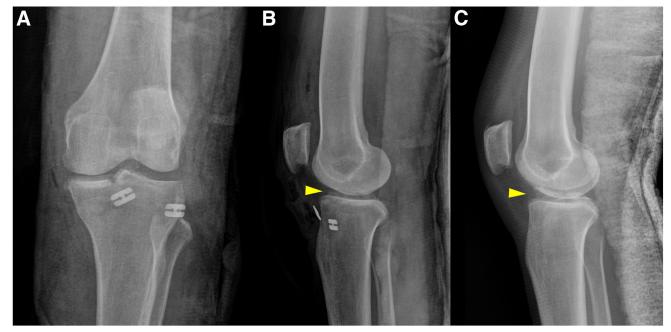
(A-B) The postoperative radiographs reveal the suspension buttons placed over the tunnels' apertures in different directions (A). The fragment is reduced after fixation (B, yellow arrowhead), comparing to preoperative radiograph (C, yellow arrowhead).
